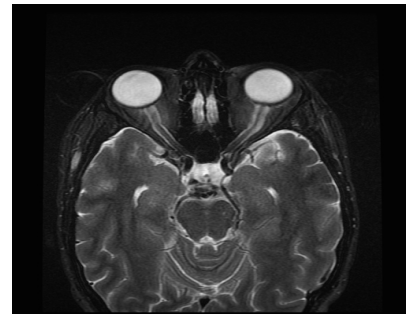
Axial T2 sequence of brain MRI showing significant flattening of optic nerve-globe junction, with expansion of CSF filled peri-optic nerve sheath space.
